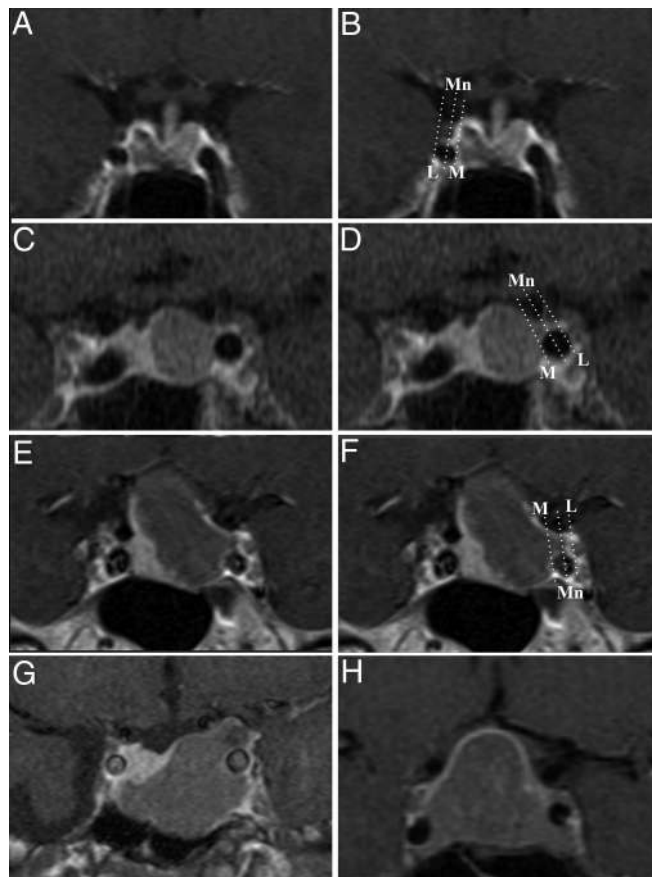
Knosp classification of tumors. All images are preoperative T1-weighted contrasted coronal images. A and B, Knosp grade 0 tumor. Same patient without (A) and with (B) *lines* drawn on the carotid tangents. Note that all tumor is medial to the medial carotid tangent. C and D, Knosp grade 1 tumor. Same patient without (C) and with (D) *lines* drawn on carotid tangents. Note that tumor crosses the medial tangent but does not cross the median tangent. E and F, Same patient without (E) and with (F) *lines* drawn on carotid tangents. Note that tumor crosses the median tangent but does not cross the lateral carotid tangent. G, Knosp grade 3 tumor. Tumor crosses the lateral carotid tangent. H, Knosp grade 4 tumor. Tumor encircles the carotid artery. M, Medial carotid tangent; Mn, median carotid tangent; L, lateral carotid tangent.
